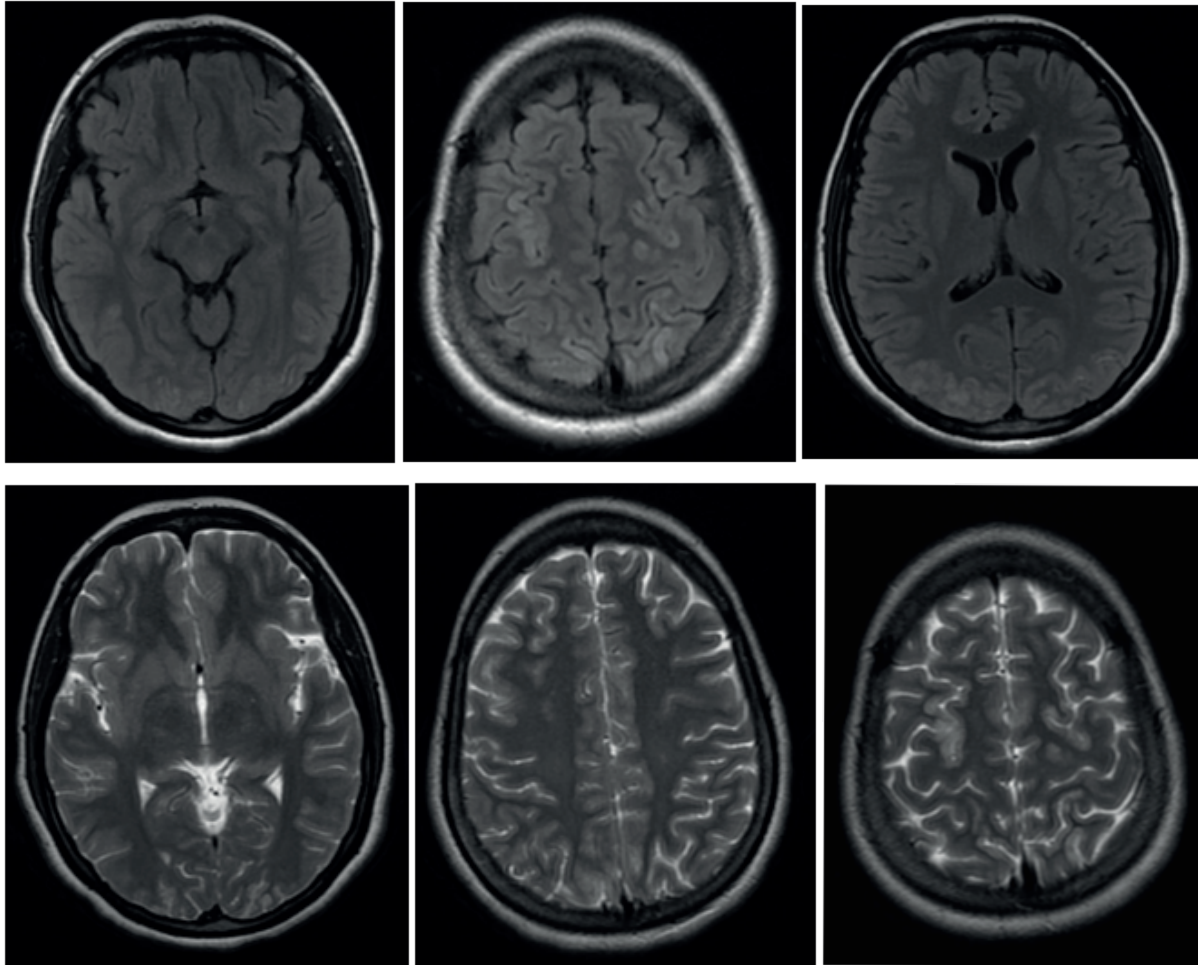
AXIAL T2 & AXIAL T2 FLAIR images: showing hyper intensities in the bilateral parietal and occipital lobes.
